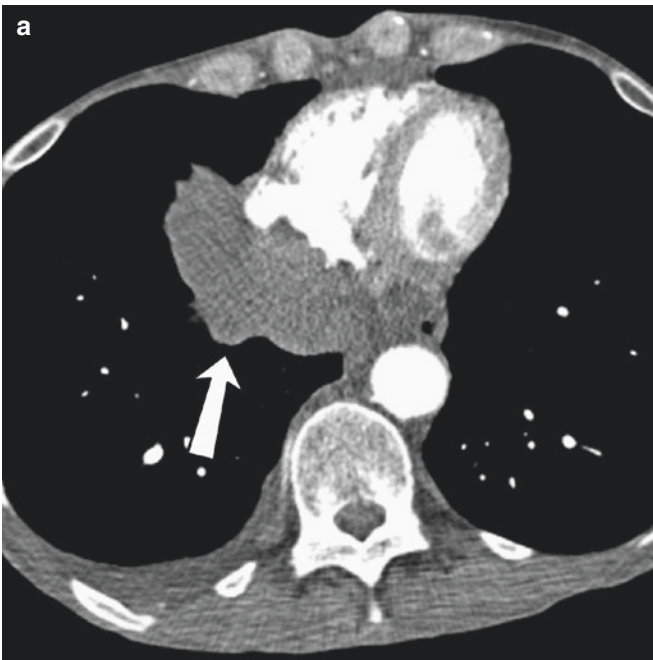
Mesothelioma. Axial CT scan shows a large pericardial mass (arrow) adjacent to the right atrioventricular groove with mass effect and slight displacement of the right chambers consistent with pericardial mesothelioma
